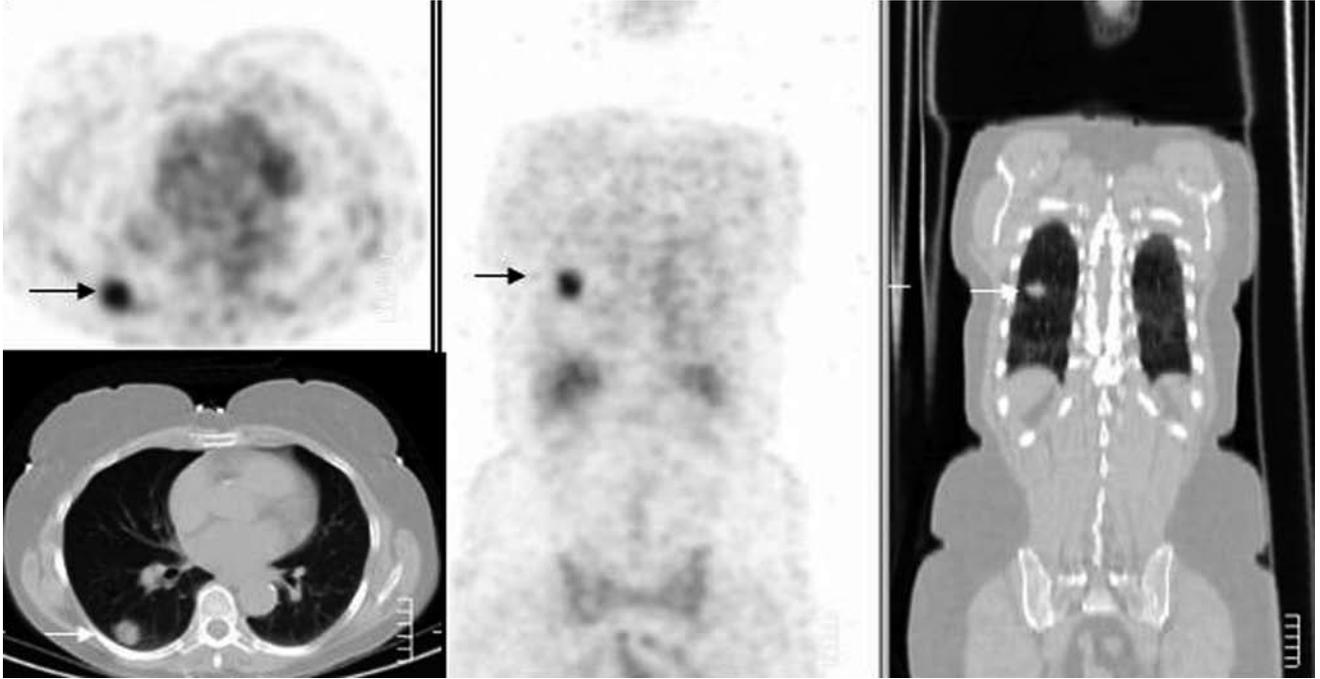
A solitary pulmonary nodule was detected incidentally by CT in the right lung (white arrow) in a 56-year-old female. The lesion was FDG-avid (black arrow) and the final diagnosis was made as adenocarcinoma after transthoracic lung biopsy. There was no hilar enlargement or metastasis elsewhere and FDG-PET was useful for initial staging of the patient.
